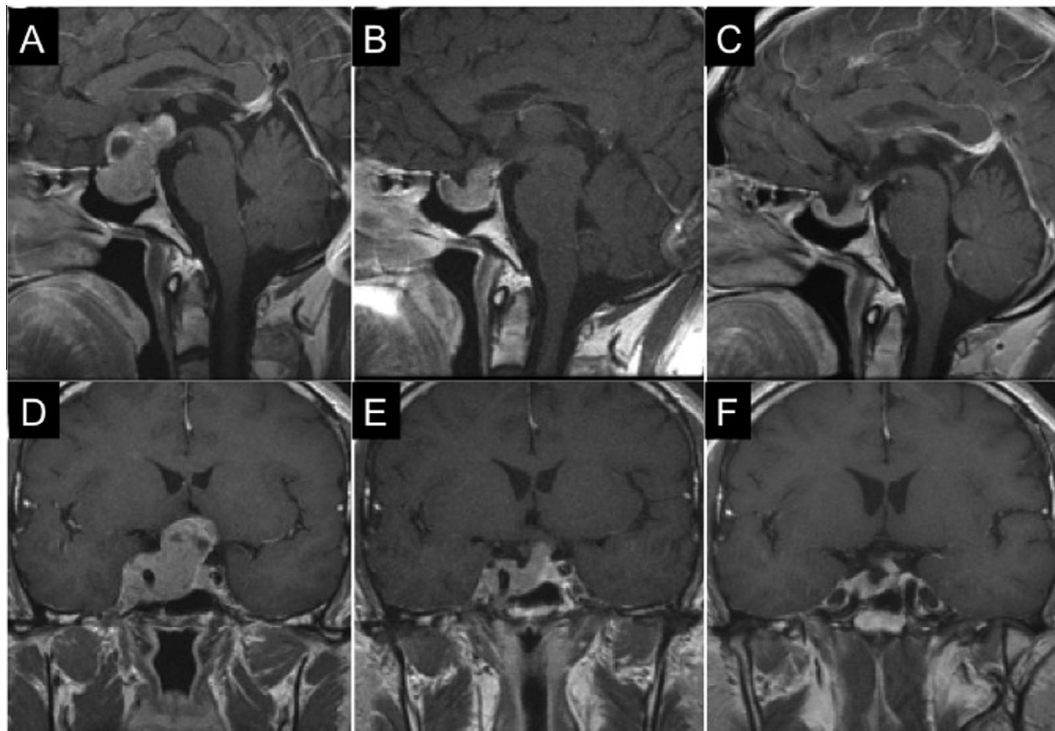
Initial post-gadolinium T1-weighted MRI (A: sagittal; D: coronal) of a 41-year-old man who presented with headaches and blurred vision secondary to a macroprolactinoma. His serum prolactin level was 3711.0 ng/mL. Bromocriptine therapy was initiated and a follow-up MRI (B: sagittal; E: coronal) 3 months later showed significant tumor shrinkage, and he had a serum prolactin level of 196.7 ng/mL. One year later, the patient developed resistance to bromocriptine with recurrent tumor growth. Bromocriptine was switched to cabergoline and a follow-up MRI (C: sagittal; F: coronal) 4 months later showed further shrinkage of the tumor volume. His serum prolactin level was 56.7 ng/mL.
